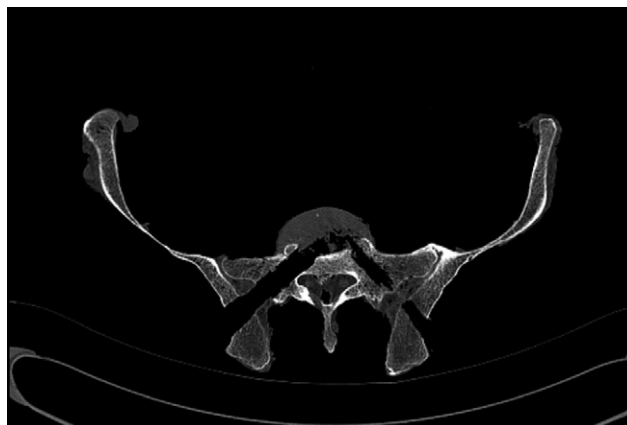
CT scan visualizing transosseous tunnel at level of isthmus and disc space.
